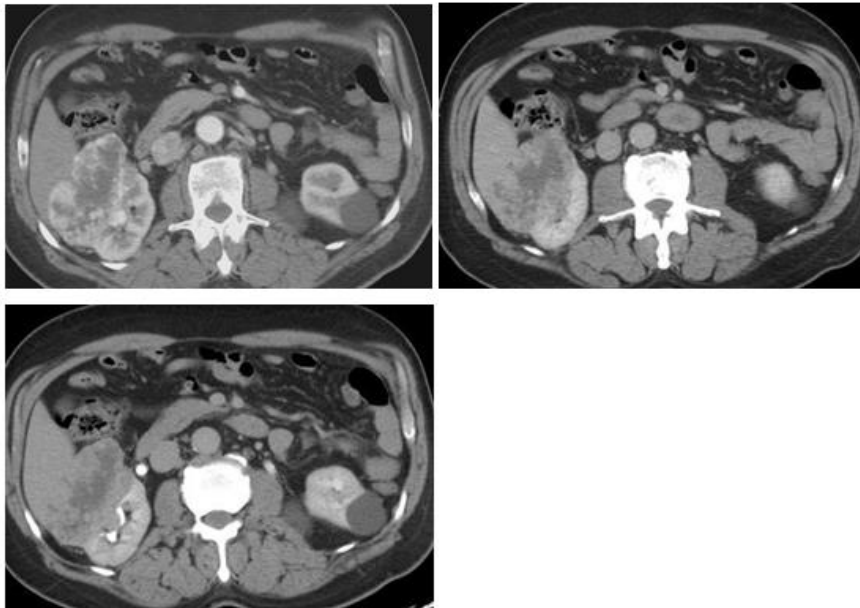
axial images of triphasic CT(corticomedullary , nephrographic and delayed phases) show right large heterogeneous enhanced solid mass , early avid enhanced at cortico-medullary phase and wash out atdelayed phase .
